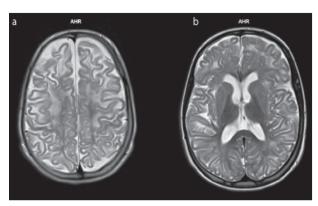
Cerebral MRI of the patient. Axial T2 weighted image. Multiple white matter hyperintensities with a frontal predomination (a) and without major deep and periventricular abnormalities (b). Affection of arcuate U fibers and centripetal involvement are shown (a and b).
